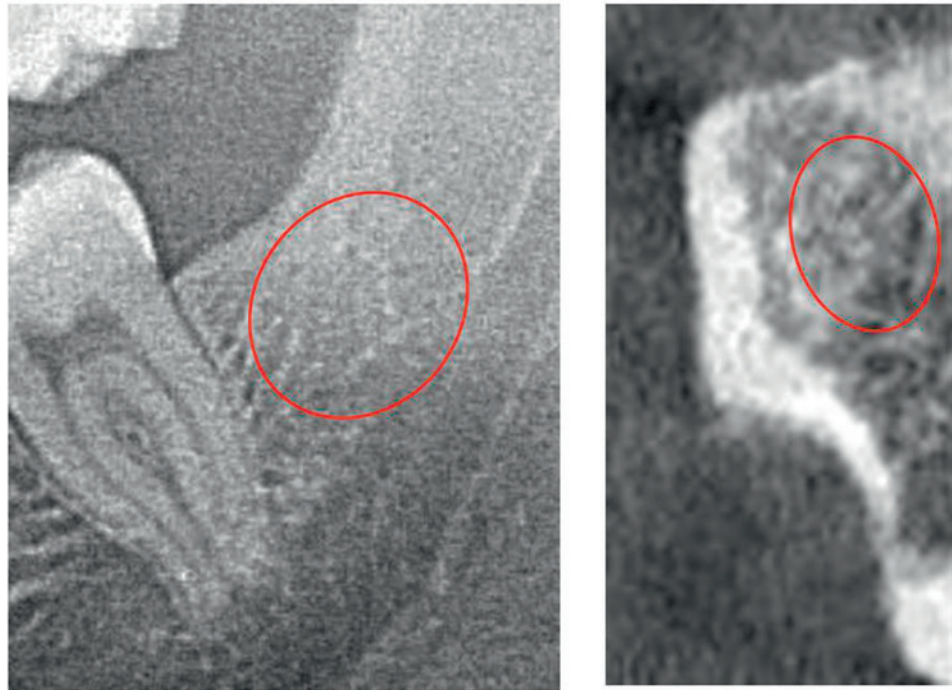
Panoramic radiograph OPG and sectional DVT/CBCT image.
